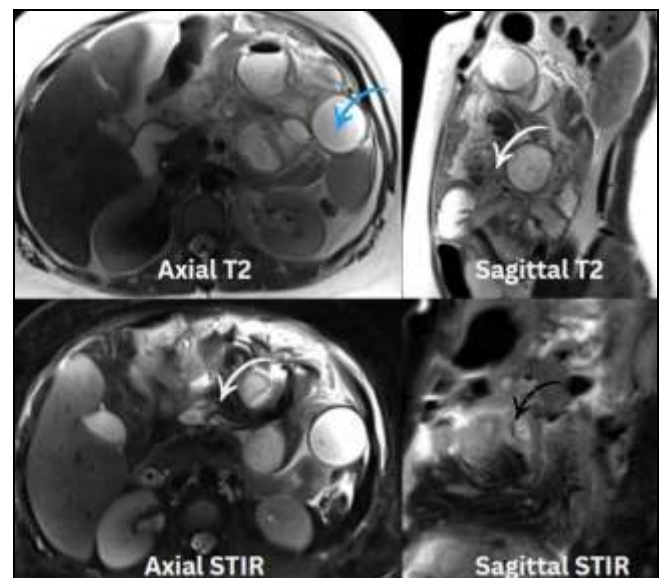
MRI of abdomen without contrast
